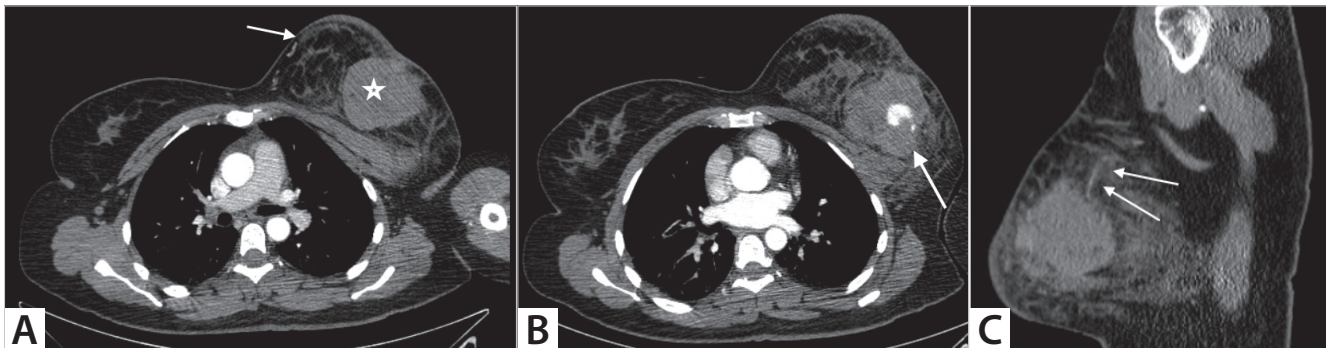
(A,B). Axial and (C) Sagittal intravenous enhanced CT images. (A) There is a multilobulated nodular lesion compatible with hematoma extending from upper inner quadrant to lower-outer quadrant of left breast (star). Additionally, the breast parenchyma is heterogeneous with diffuse skin and subcutaneous tissue thickness (arrow). (B) Hyperdense area at the central part of hematoma reveals contrast material extravasation due to active bleeding. (C) There is a thin enhancing arterial structure extending into the hematoma (arrows). This artery is compatible with one of lateral mammarian artery branch, which is originated from lateral thoracic artery is the source of active bleeding.
